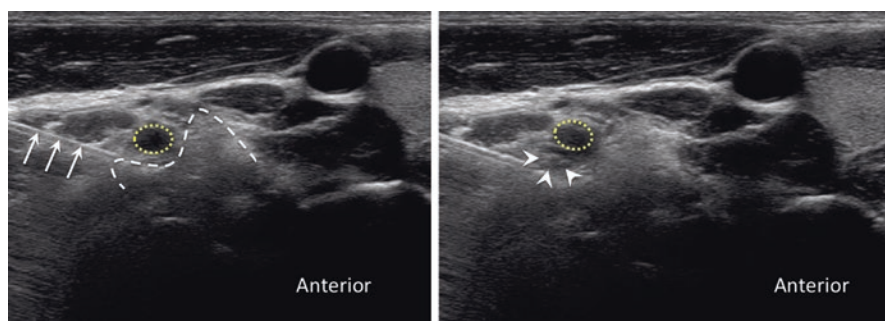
Injection around the nerve root. The left sonography showed the needle inserted on the dorsal side of the nerve root. The right sonography showed the injectate. The nerve root was highlighted with yellow dotted line
